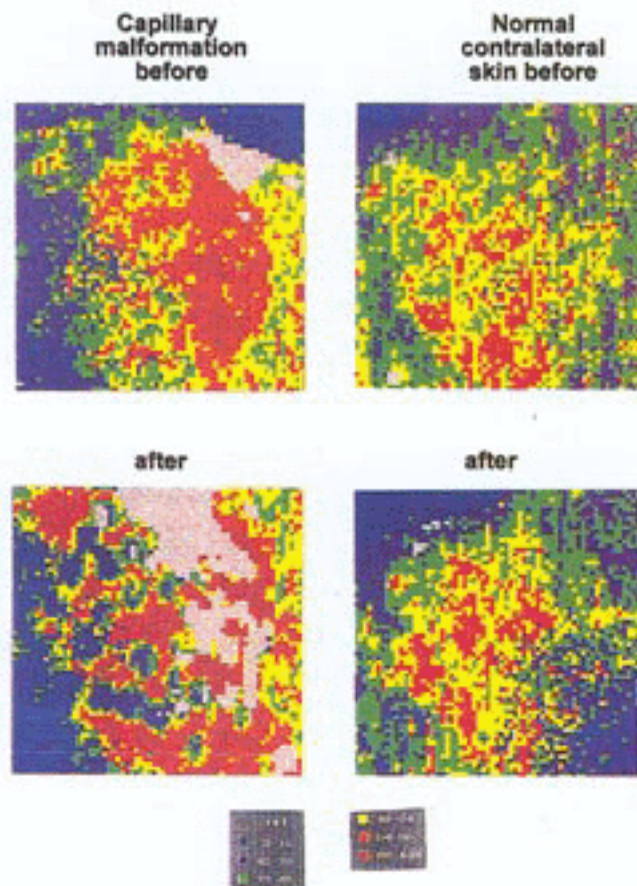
Laser Doppler perfusion imaging before and directly after pulsed dye laser treatment of the right cheek, in comparison with the left untreated cheek. (Same patient as in Fig. 2). The grey colour is caused by high light absorption of the blue discoloration after the treatment (see Discussion).
